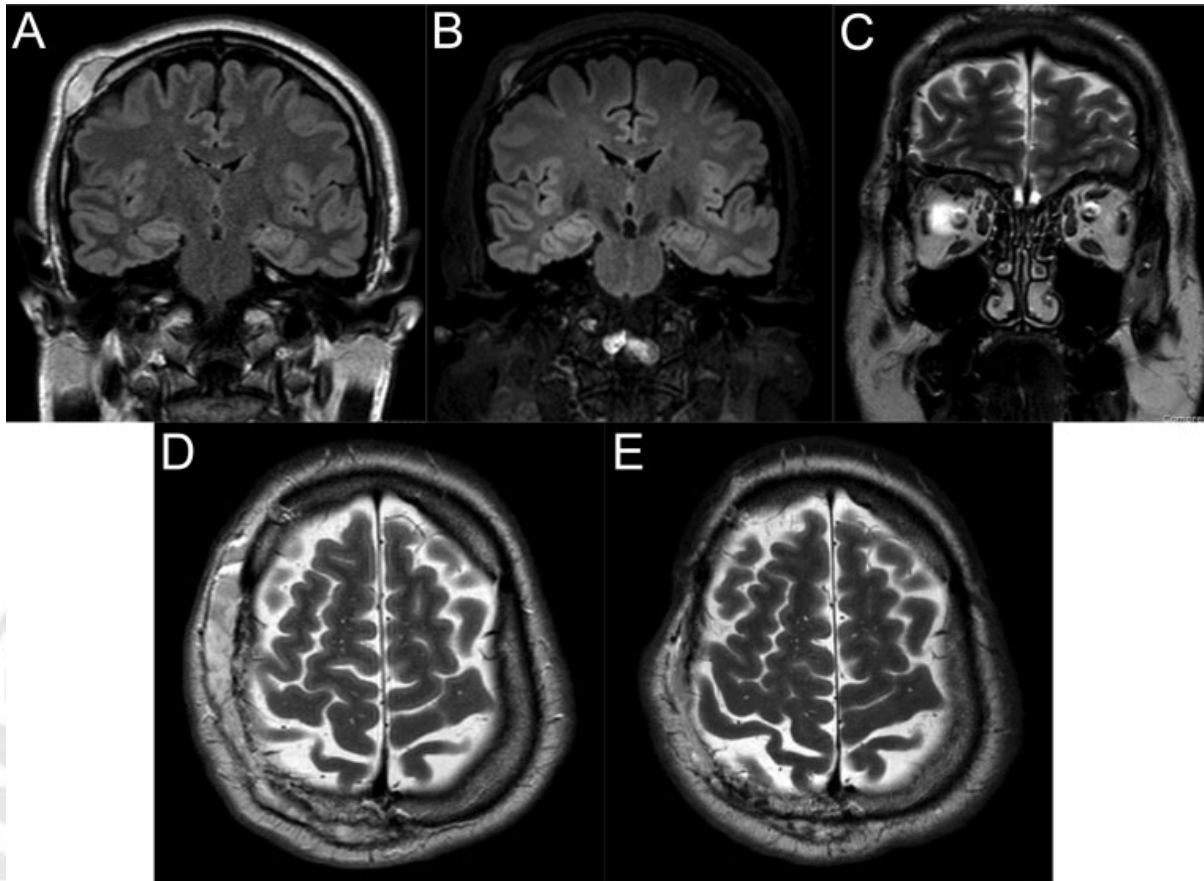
(a) Preoperative coronal fluid attenuation inversion recovery (FLAIR) magnetic resonance imaging (MRI). (b) Postoperative coronal FLAIR MRI. (c) Postoperative coronal T2-weighted MRI. The volume and extension of the scalp arteriovenous malformation (AVM) is reduced, as well as the intraorbital compression. (d) Preoperative axial T2-weighted MRI. (e) Postoperative axial T2-weighted MRI showing the reduction of the scalp swelling due to the AVM.
